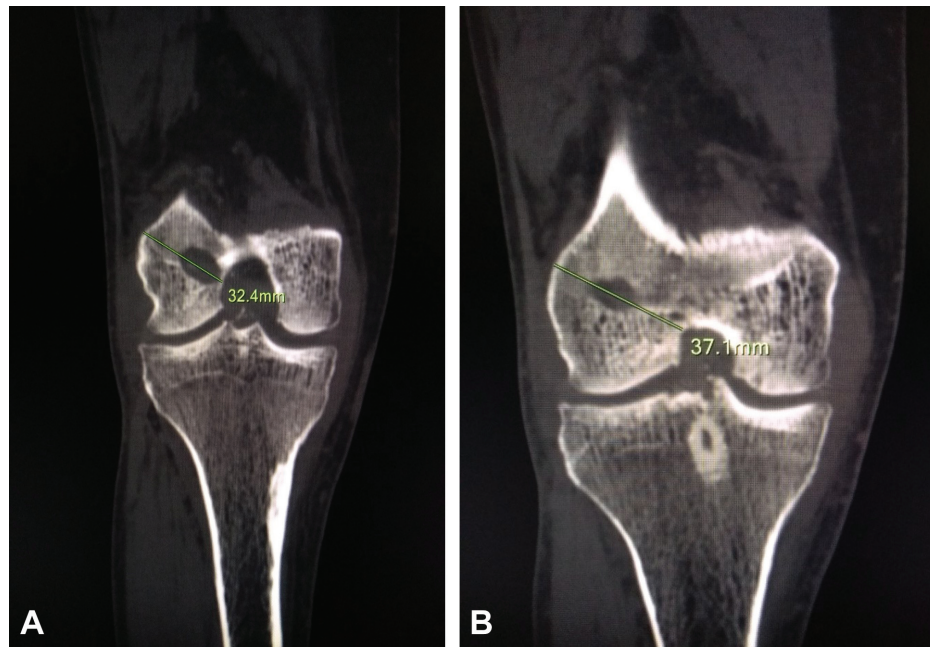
Coronal computed tomography images of the same patient showing two different femoral tunnel lengths at two different positions.
